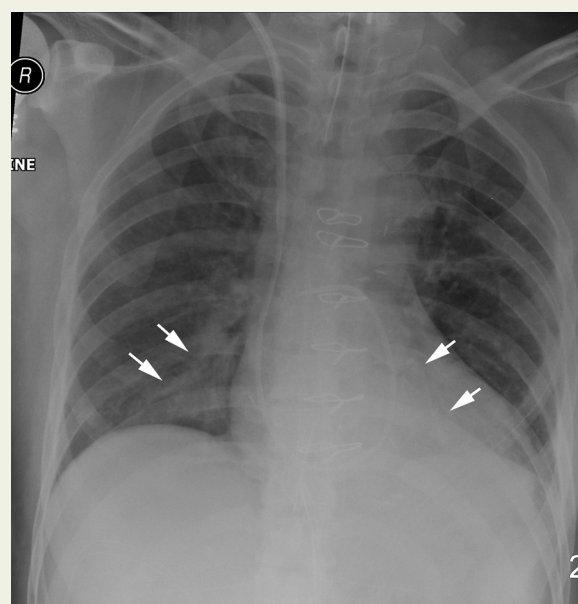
Supine AP chest radiograph in a 55-year-old man demonstrates grade 2 bibasilar atelectasis (arrows).
